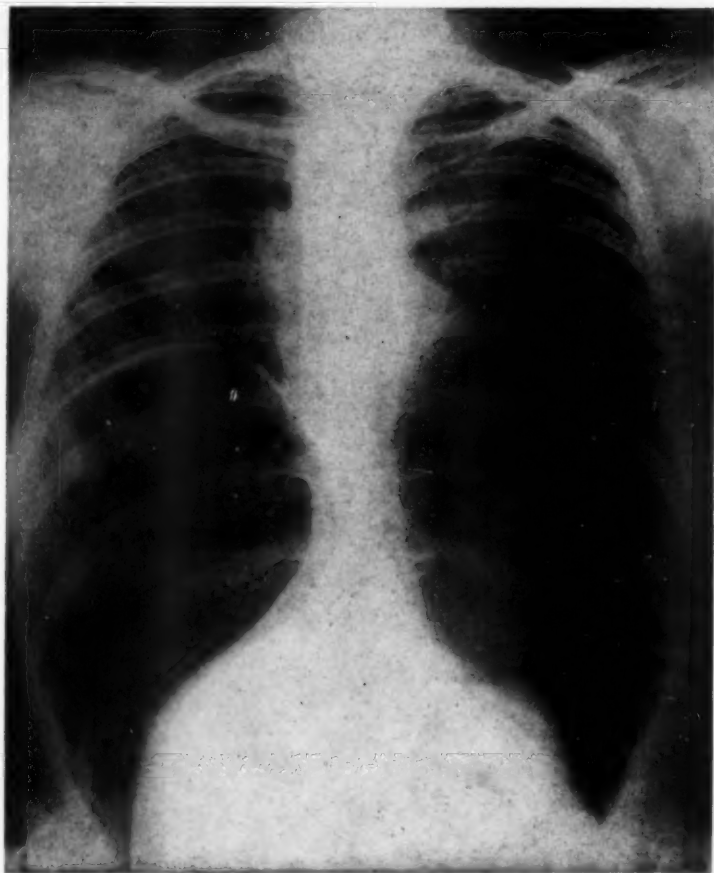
Chest roentgenogram taken April 3, 1950, showing prompt clearing and disappearance of cavity at the left root following left phreniclasia. Cavity still present at right apex.
